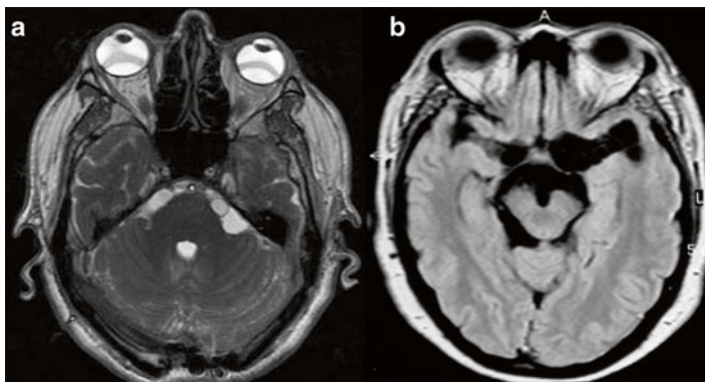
MRI of extraparenchymal neurocysticercosis. (a) Cysticerci located in the cerebellopontine cistern (FIESTA sequence). (b) Cysticerci located in the basal subarachnoidal cisterns
